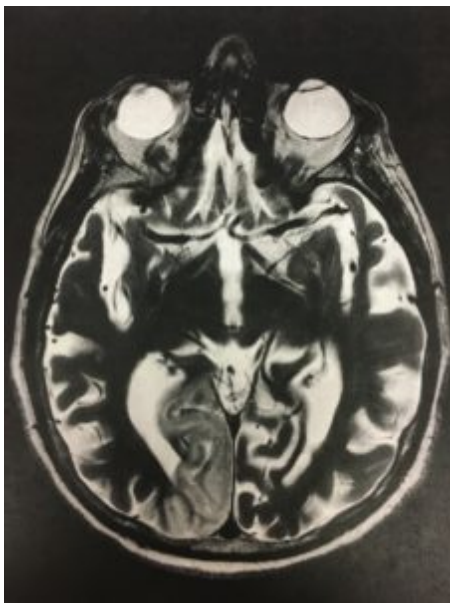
Axial section of the patient's MRI of the brain with contrast. An infarction of the right occipital cortex can be seen as hyperintensity of the gyri in that region. [Click to enlarge](#)
